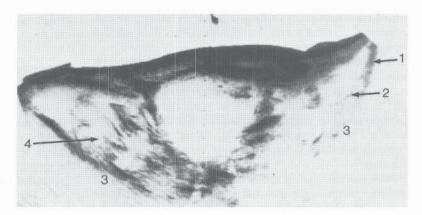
Ultrasonographic findings in soft tissue bleeding in the iliopsoas muscle on the right. 1-Normal iliopsoas. 2-Fascial plane. 3-Iliac bone. 4-Bleeding in the iliopsoas.
